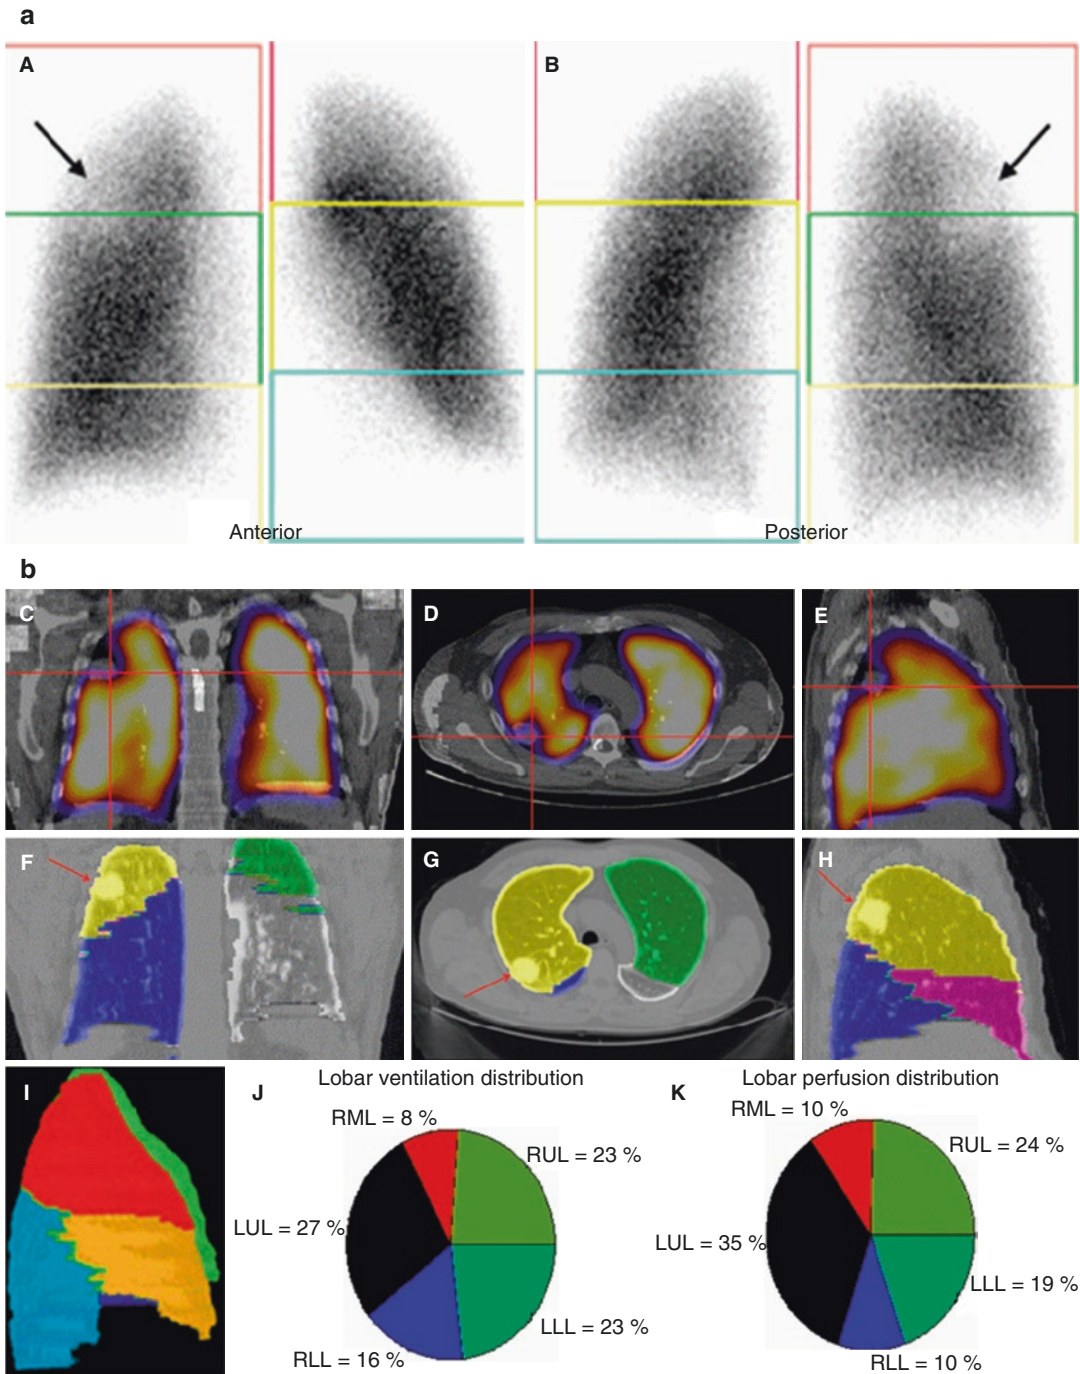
(a) Anterior (A) and posterior (B) planar images in a patient with a right lung carcinoma (arrowed). The exact lobar location of the tumour cannot be determined on the planar imaging. (b) Fused SPECT/CT perfusion images in the coronal (C), transverse (D) and sagittal (E) planes show the tumour and corresponding perfusion defect (indicated by cursors). Corresponding CT scan slices in the coronal (F), transverse (G) and sagittal (H)
